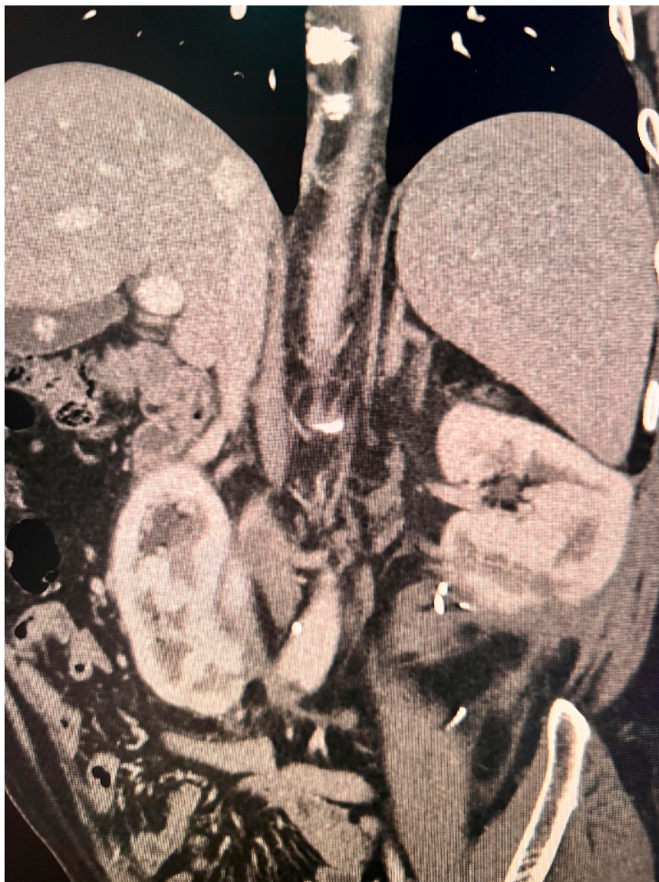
Computed tomography follow-up revealed normal anatomical findings.
